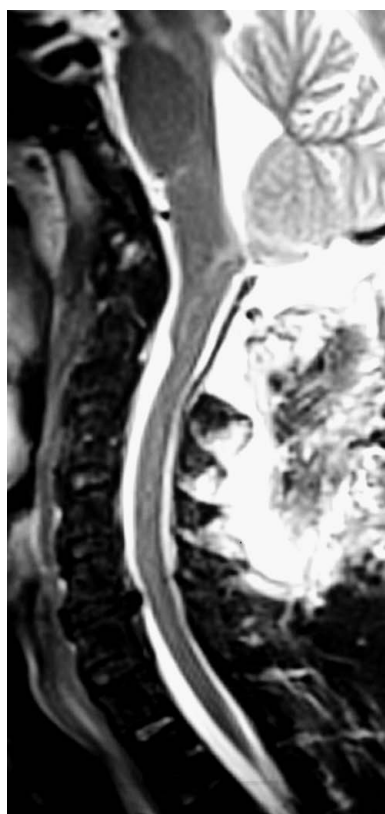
Post-operative sagittal contrast-enhanced T2WI MRI scan
